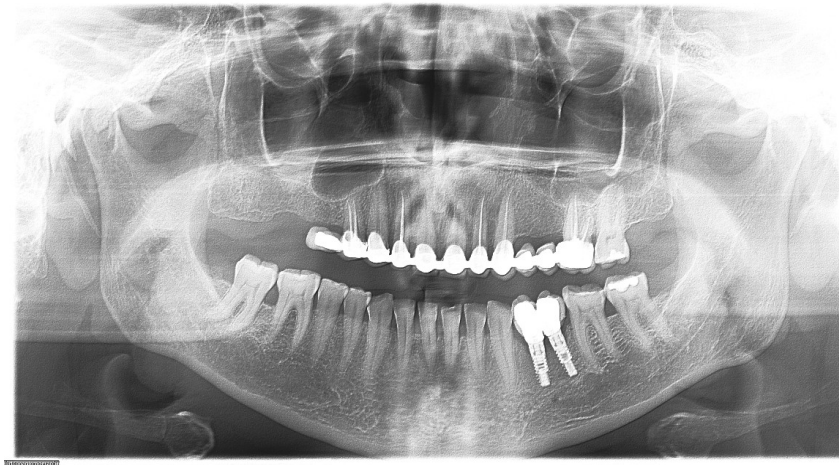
Radiographic evaluation of two adjacent implants 6 months after prosthetic treatment.
